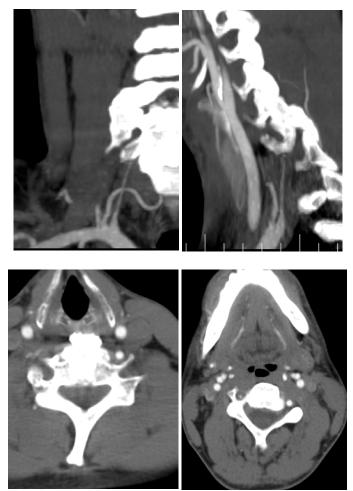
Angio-CT scan of the neck showing signs of right VA dissection in V2 segment (A – coronal view, B – lateral view, C, D – axial view)
